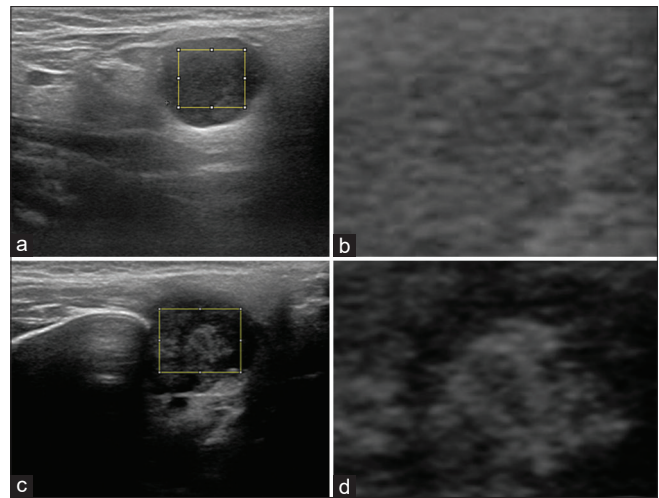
A square block was sampled from a patient with a right parotid tumor (a). A representative US picture was selected for further texture analysis (b). The pathologic report revealed pleomorphic adenoma. Another square block was sampled from a patient with a right parotid tumor with a diagnosis of mucoepidermoid carcinoma (c). Another representative US picture was selected for further texture analysis (d). US: Ultrasound
